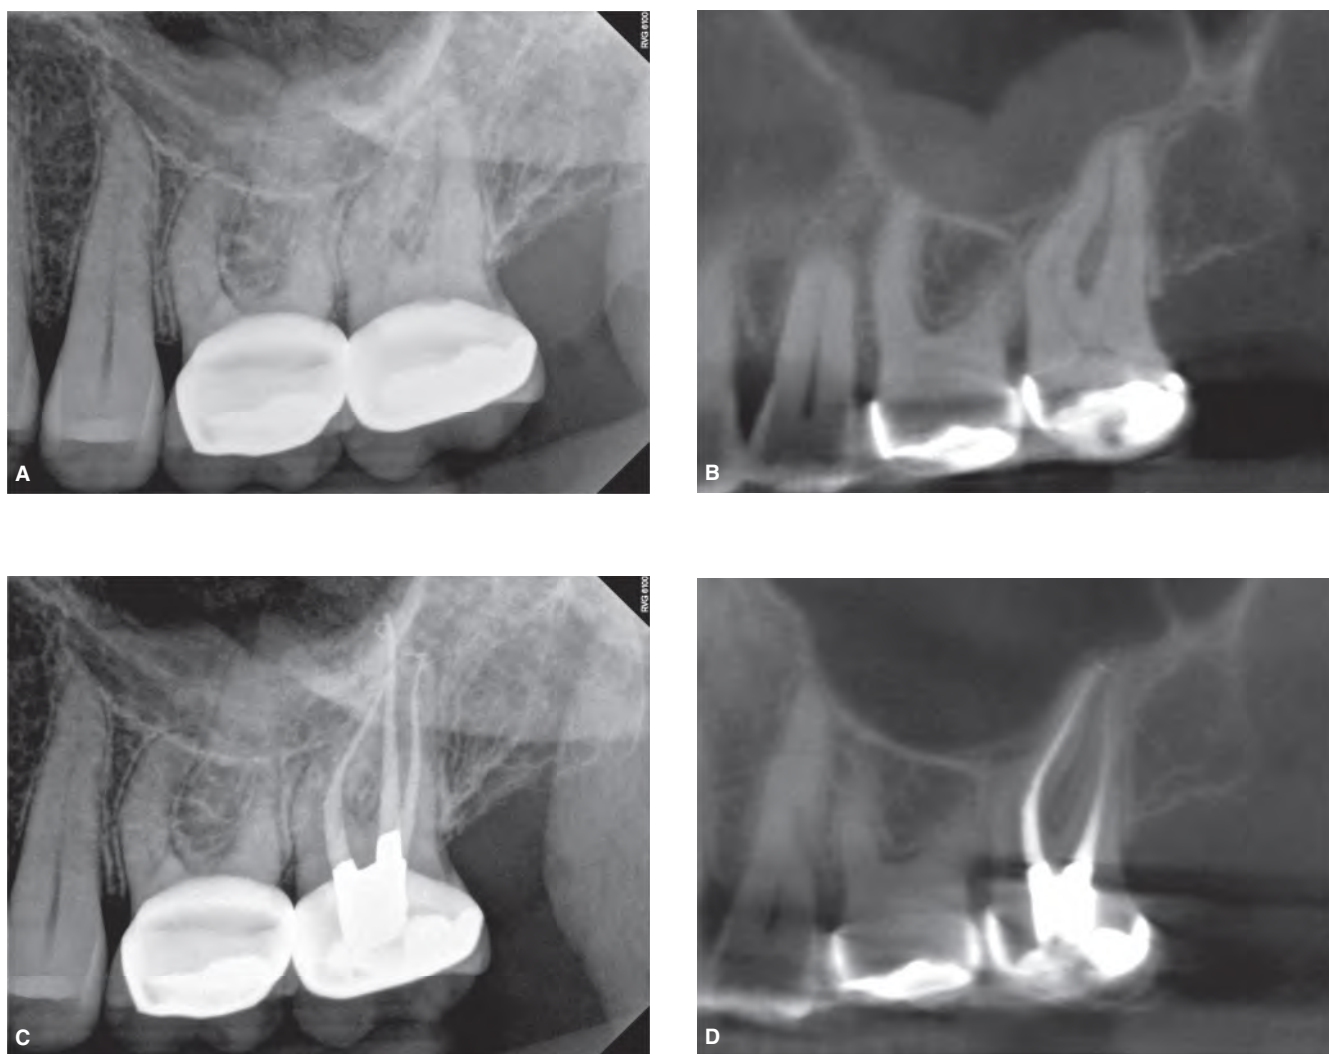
Periapical mucositis without osseous changes. A. Periapical radiograph of the maxillary left posterior dentition. Clinical endodontic examination confirmed the second molar was necrotic. B. Sagittal CBCT image of the maxillary left posterior region revealing mucosal edema in the floor of the left maxillary sinus, but without evidence of alveolar bone damage. C. Periapical radiograph following endodontic treatment of the second molar. D. 3-month postoperative sagittal CBCT image showing full resolution of the mucosal edema.
